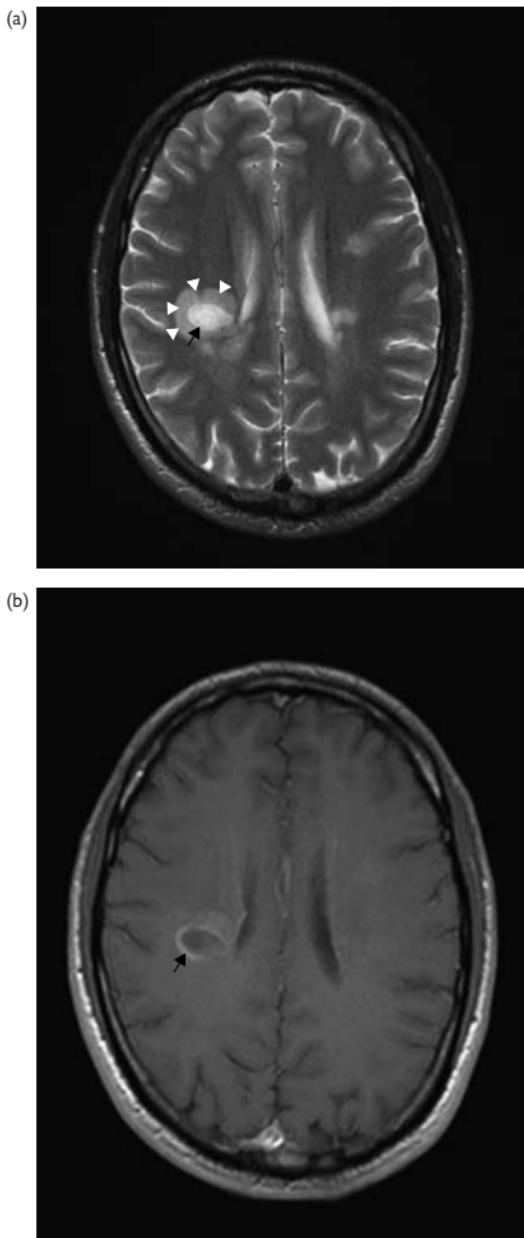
Acute presentation of MS. (a) Axial T2-weighted and (b) axial post-contrast enhanced MRI. Several rounded hyperintense lesions in the deep cerebral white matter. The largest in the right corona radiata ((a) black arrow)) is surrounded by a halo of slightly less hyperintensity ((a) white arrowheads) and demonstrates an incomplete ring of enhancement ((b) black arrow).
